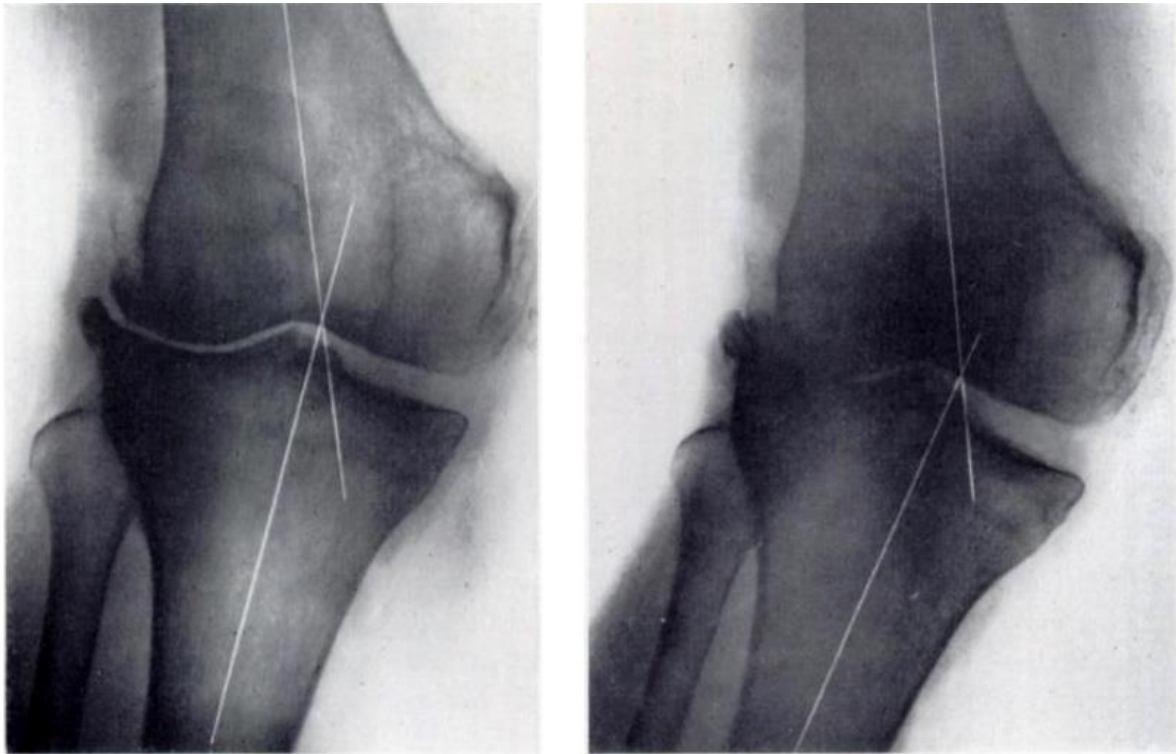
Short knee views only provide limited understanding of alignment and have been replaced with the conventional long leg alignment radiograph as the gold standard examination. Figure copied from [81]
